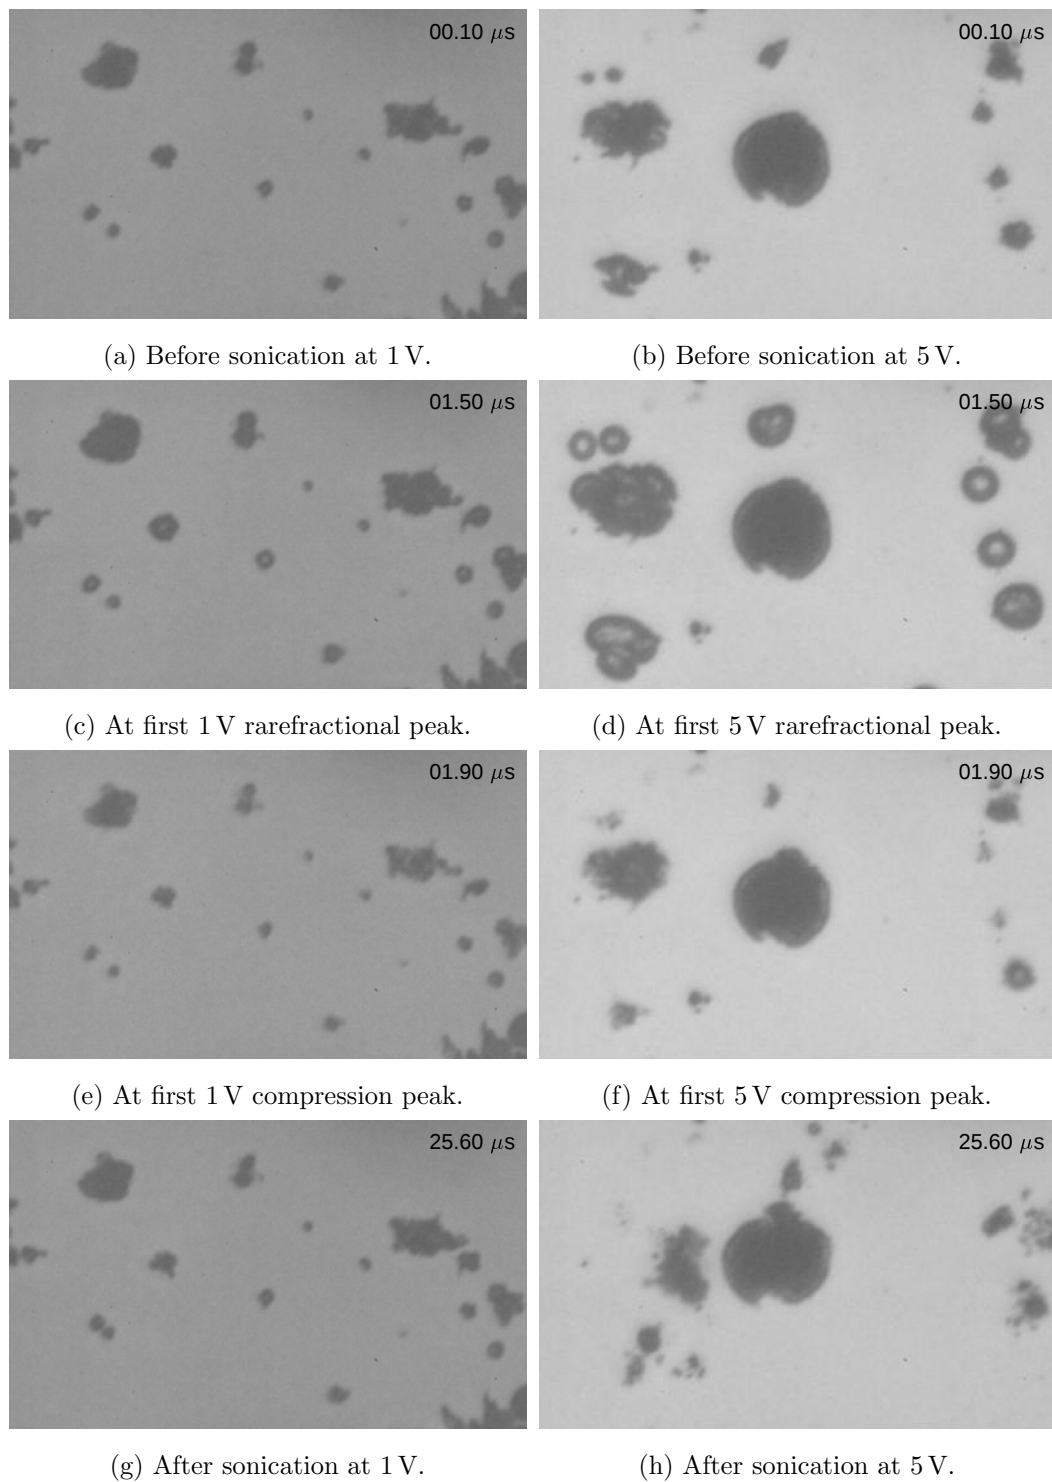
High-speed frames showing the impact of the amplitude of the applied ultrasound on AB2 antibubbles. The figures on the left show frames of AB2 antibubbles at different times during ultrasound exposure at an amplitude of 1 V, whilst the figures on the right show the comparative frames of AB2 antibubbles during ultrasound exposure at an amplitude of 5 V.
